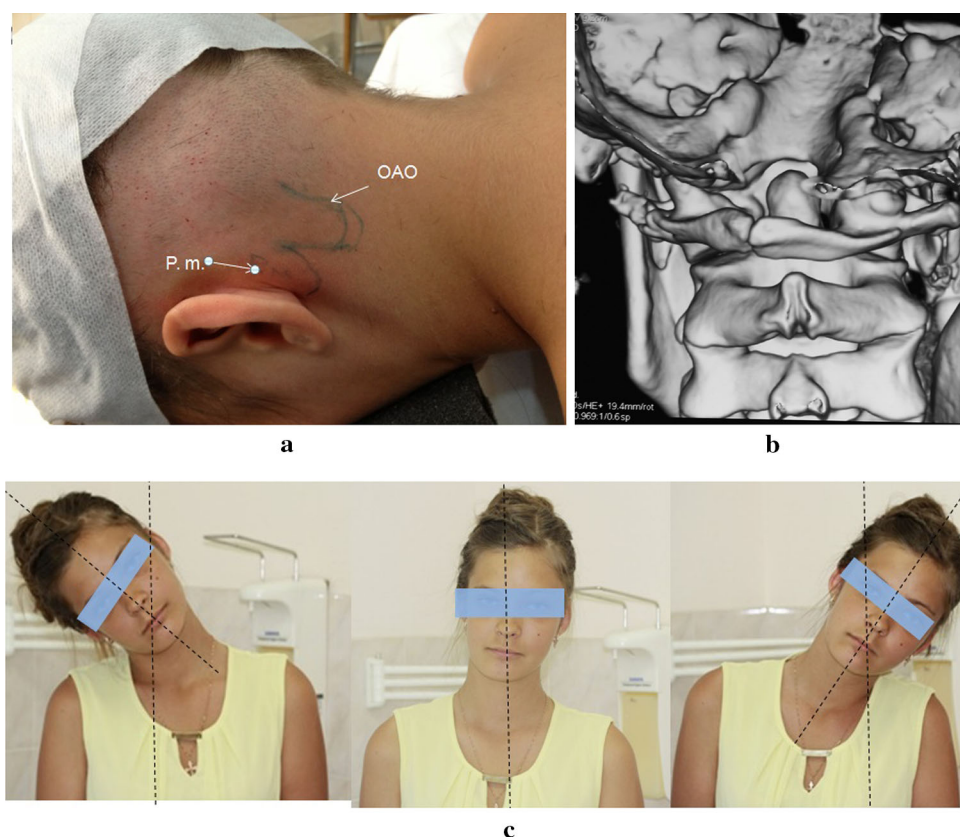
Operative view (a), post-operative CT (b), frontal photo series (c), and 3D-CT (b, c) and frontal (d) and axial (e) angio-CT scans of the 12-year-old girl (case no. 3). ROM was significantly increased
